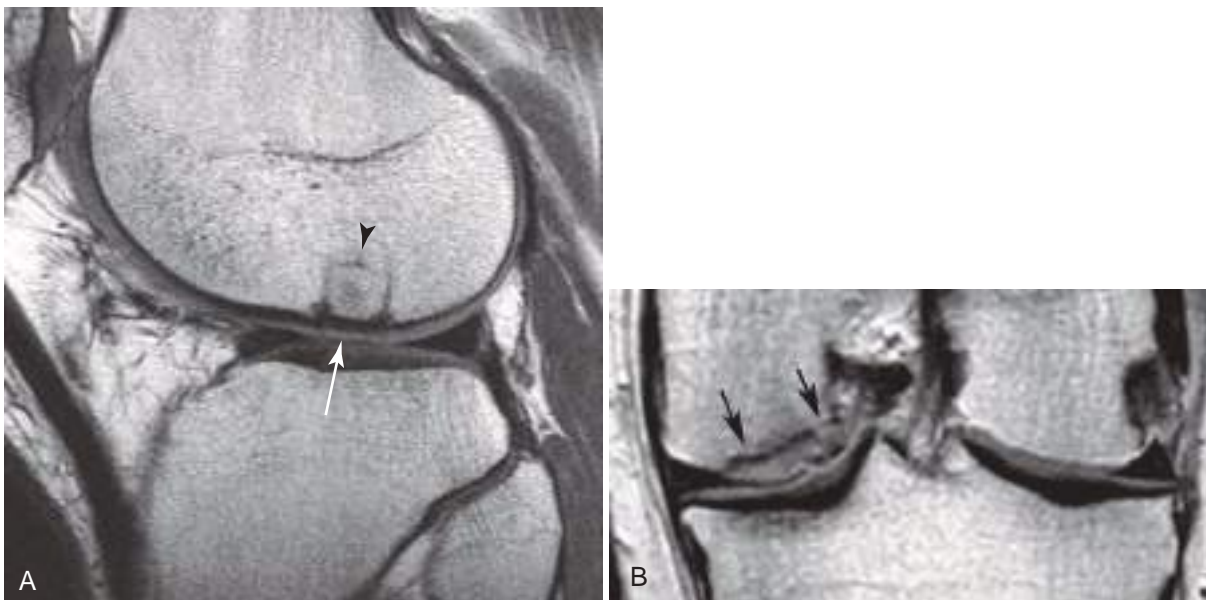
Cartilage repair techniques. (A) Autologous osteochondral transplant (OATS). Sagittal proton-density MR image. Arrowhead marks the deep margin of the cylindrical bone and cartilage plug that was harvested from the high medial femoral trochlea and placed 6 months previously to repair a high-grade lateral condyle articular cartilage defect. The plug margin is visible as parallel low-signal lines perpendicular to the articular surface. The normal graft cartilage (arrow) blends smoothly with adjacent intact cartilage. (B) Autologous chondrocyte implantation (ACI). Coronal proton-density fast spin-echo MR image shows successful repair of a medial femoral condyle osteochondral lesion. Note the intermediate-signal-intensity new cartilage (arrows) filling the defect. The mildly irregular and raised articular surface is considered to be an acceptable finding.
